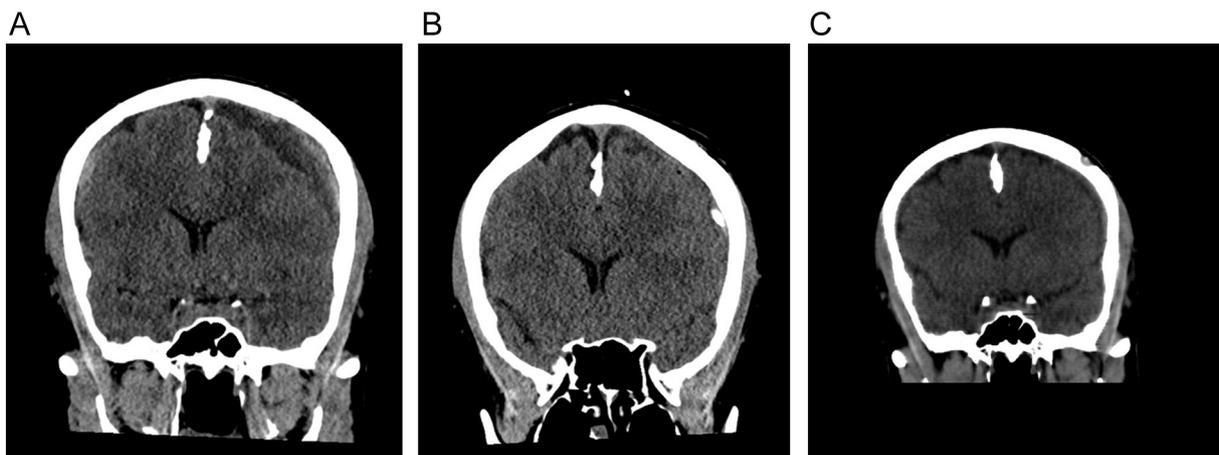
Imaging from case 2. A: Pre-operative coronal reformatted CT image demonstrating mixed attenuation left SDH with mass effect on the left lateral ventricle and mild midline shift. A small right SDH is also present. B: Post-operative coronal reformatted CT image demonstrating the SDD, with decreased size of the SDH, and decreased mass effect. A small amount of pneumocephalus is present. Right sided collection is not changed. C: 1-month follow-up CT demonstrating small residual SDH.
